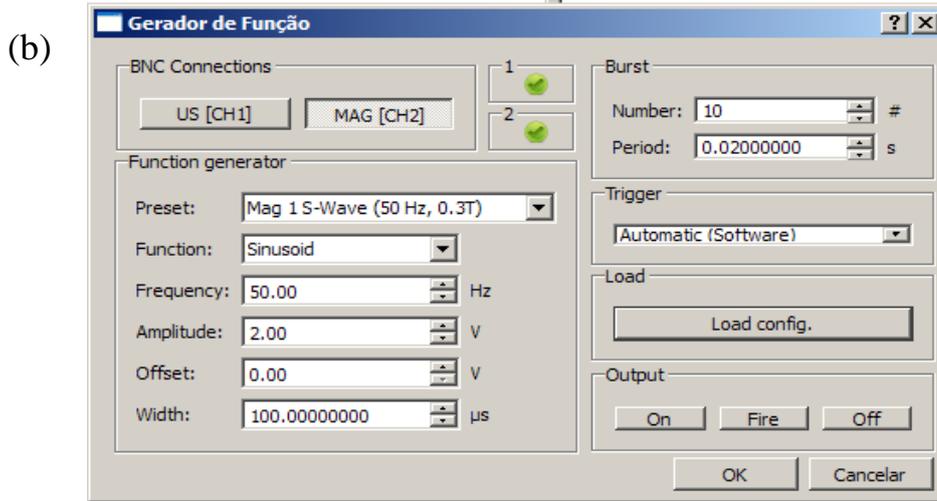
The user interfaces of an MMUS timing sequence. (a) Ultrasound acquisition and (b) Magnetic excitation.
